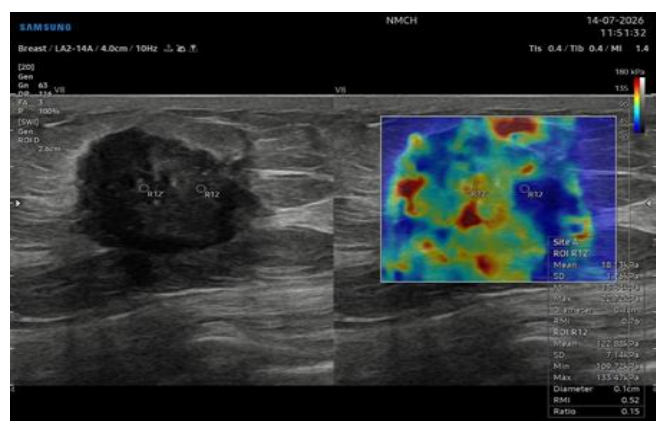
B-mode ultrasonography (left) and shear-wave elastography (right) showing an irregular hypoechoic left breast mass with marked tissue stiffness (high elasticity values), highly suggestive of malignancy (BI-RADS 5).
